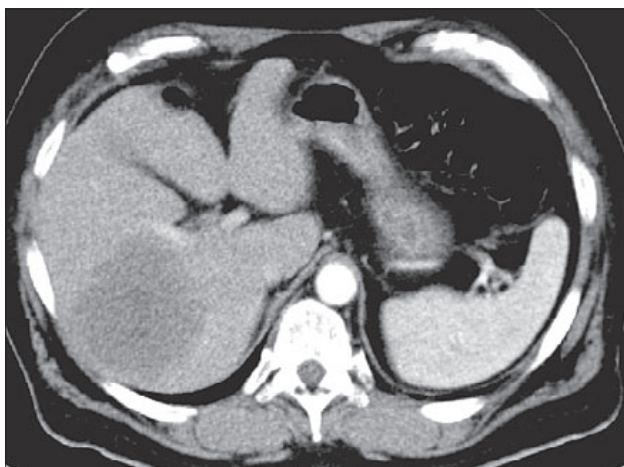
CT imagepicture of liver tuberculoma (80x65x80 mm) localized in the right lobe.
